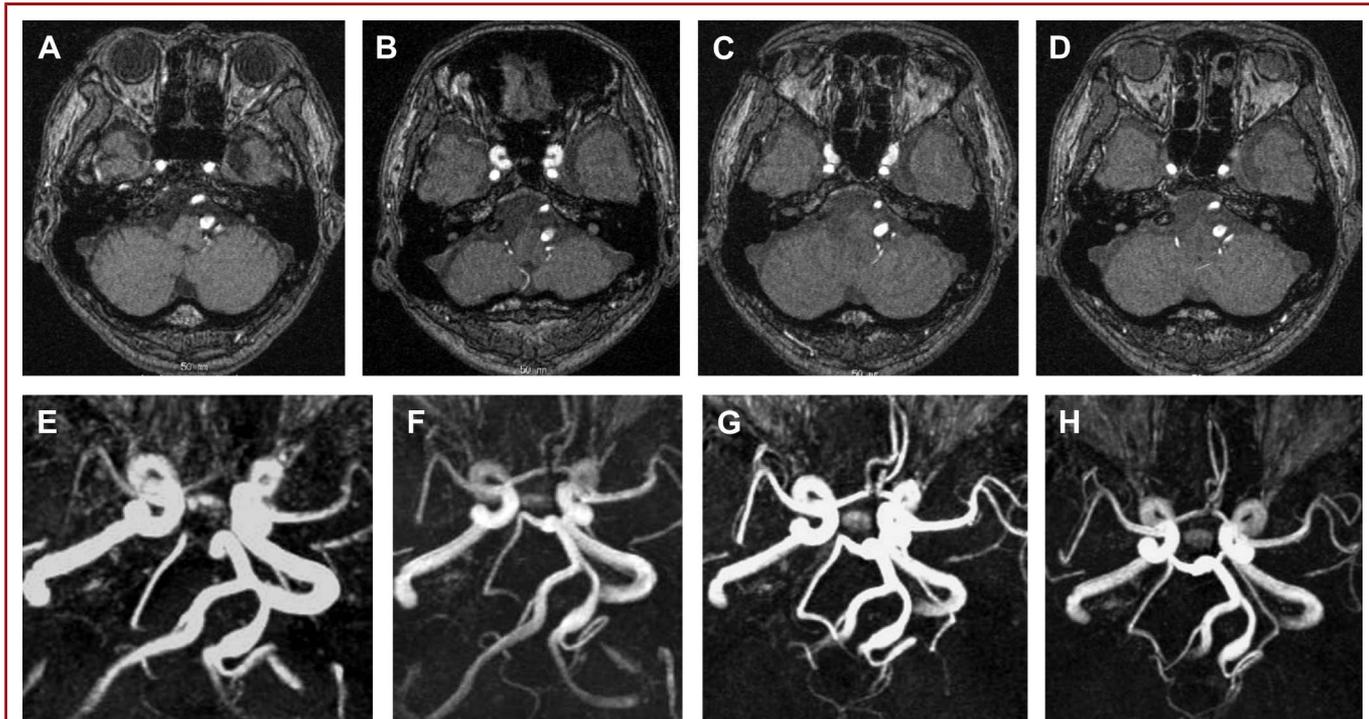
A 66-year-old man who presented with left occipital headache. A-D, magnetization-prepared rapid acquisition with gradient echo magnetic resonance imaging (MRI) demonstrating hyperintensity and dilation of the left vertebral artery. E-H, Magnetic resonance angiography showing the left vertebral artery dissecting aneurysm (VADA). A,E, on admission; B, F, 1 month later; C, G, 6 months later; D, H, 12 months later. Findings on the left VADA remained unchanged.
